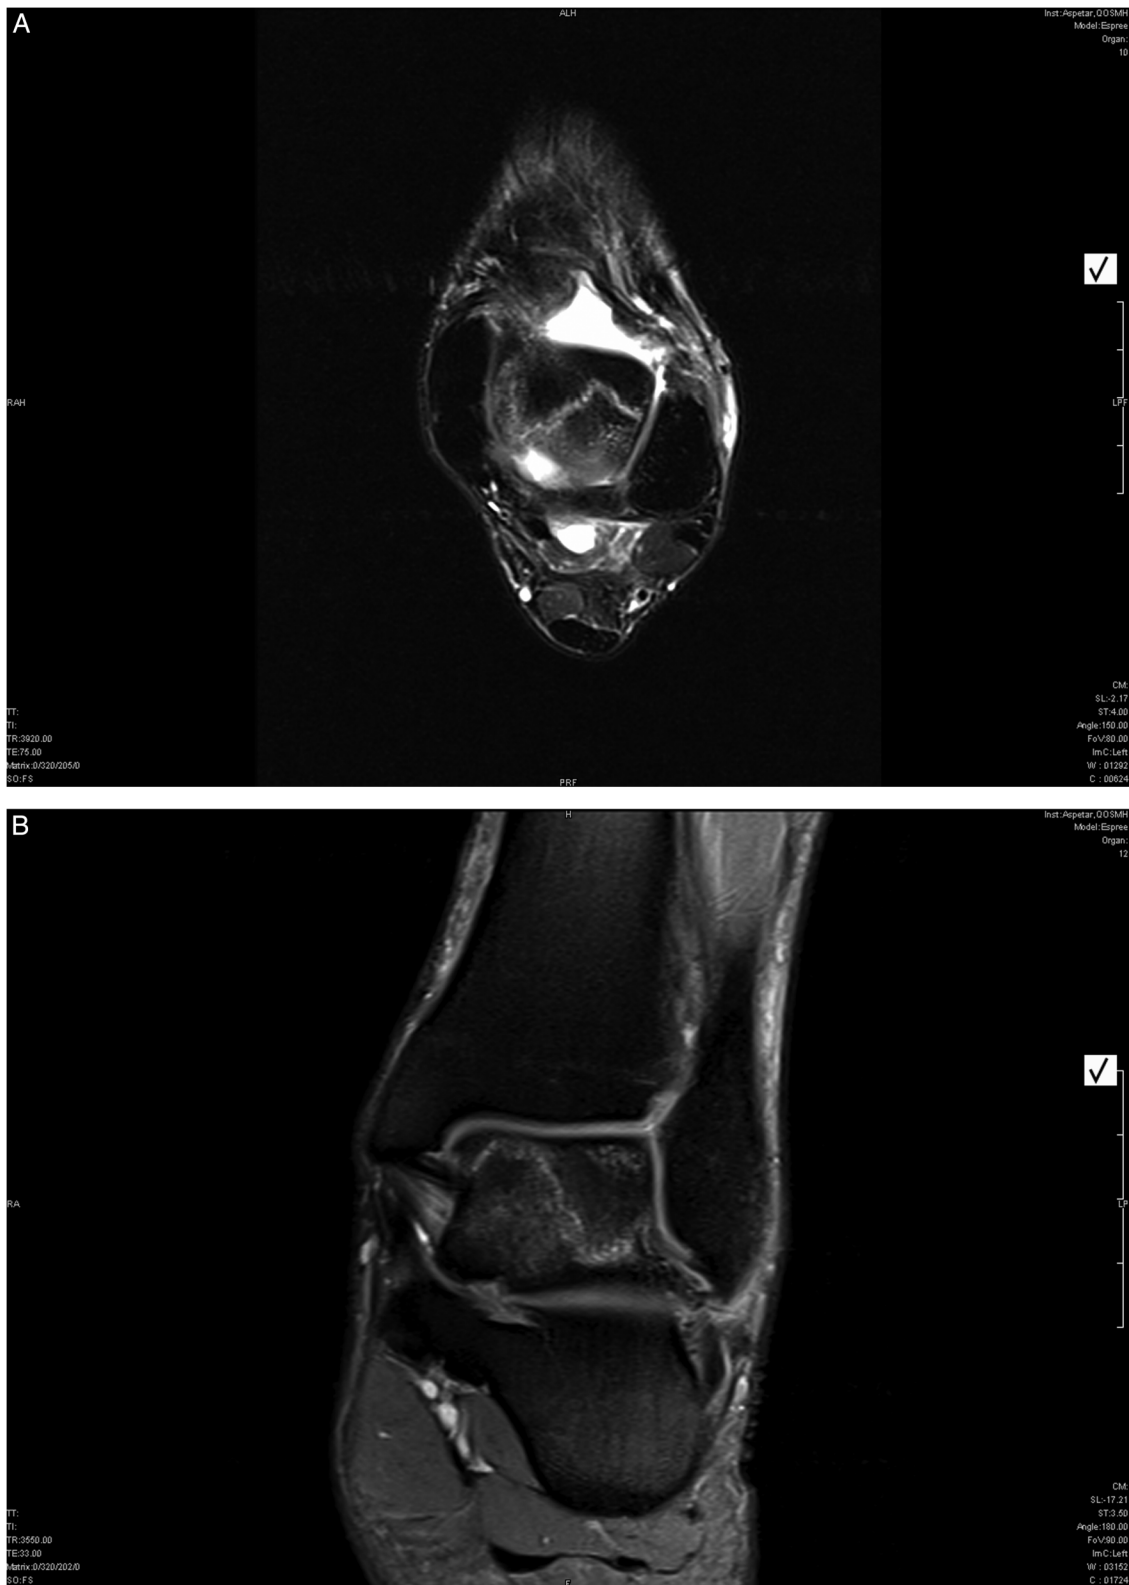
Coronal and axial ankle MRI images, revealing a non-displaced transtalar fracture.
